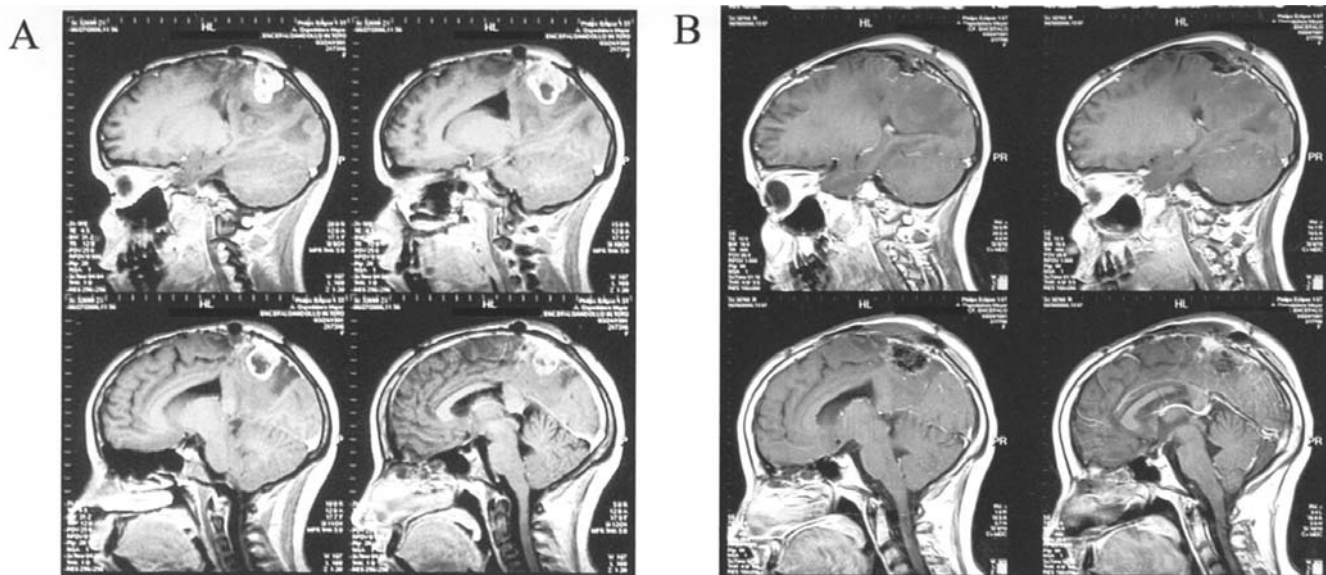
(A) Preoperative sagittal Gd-enhanced T1-weighted MR images demonstrating the tumor on the right prerolandic area. (B) Postoperative sagittal Gd-enhanced T1-weighted MR scans showing the GTR with intracavity BCNU wafer implantation.
